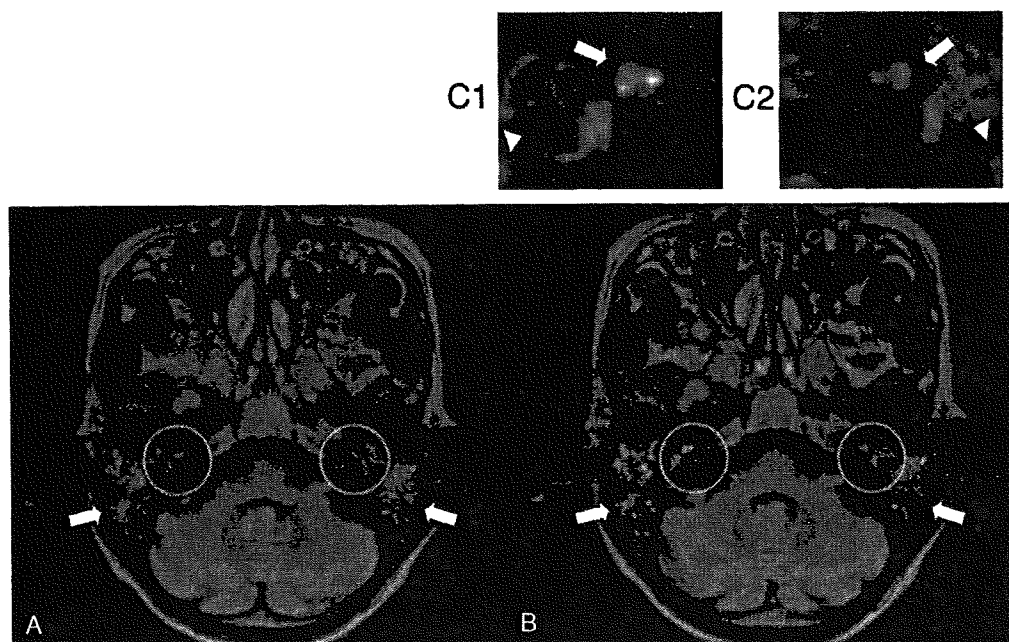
3D-FLAIR images of Case 4. A, B. Pre-contrast (A) and post-contrast (B) bilateral middle ear inflammation (arrows) and inner ear lesions (circled). A stronger signal is observed in the inner ear on the side with the worse hearing level. C. Higher-magnification image of the lesions circled in B. The cochleas (arrows) and the semicircular canals (arrowheads) are indicated in the right (C1) and left (C2) ears.
